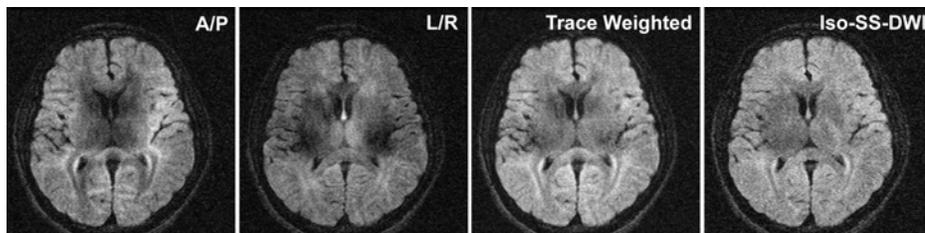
Conventional steady-state DWI and isotropic steady-state DWI with the same effective b value ( $540 \text{ s/mm}^2$ ). The first two images were acquired from the conventional steady-state DWI with diffusion weighting in A/P and L/R and were combined to produce the trace-weighted image. Isotropic steady-state DWI shows similar contrast to the trace-weighted image.
